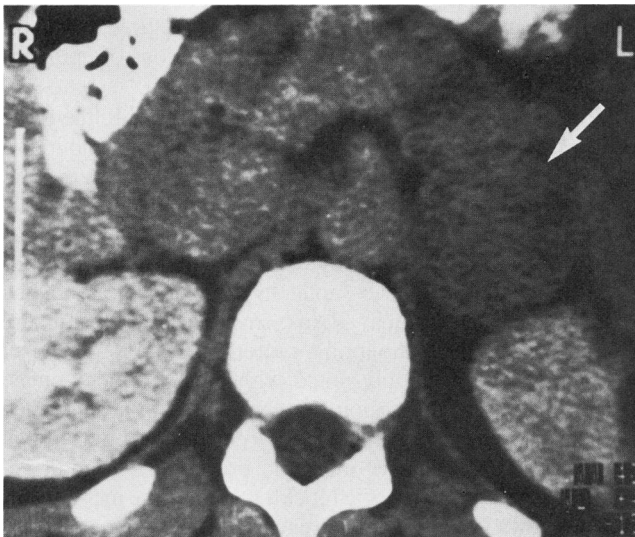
A computed tomographic scan of the abdomen with contrast. The arrow points to the left adrenal mass.
